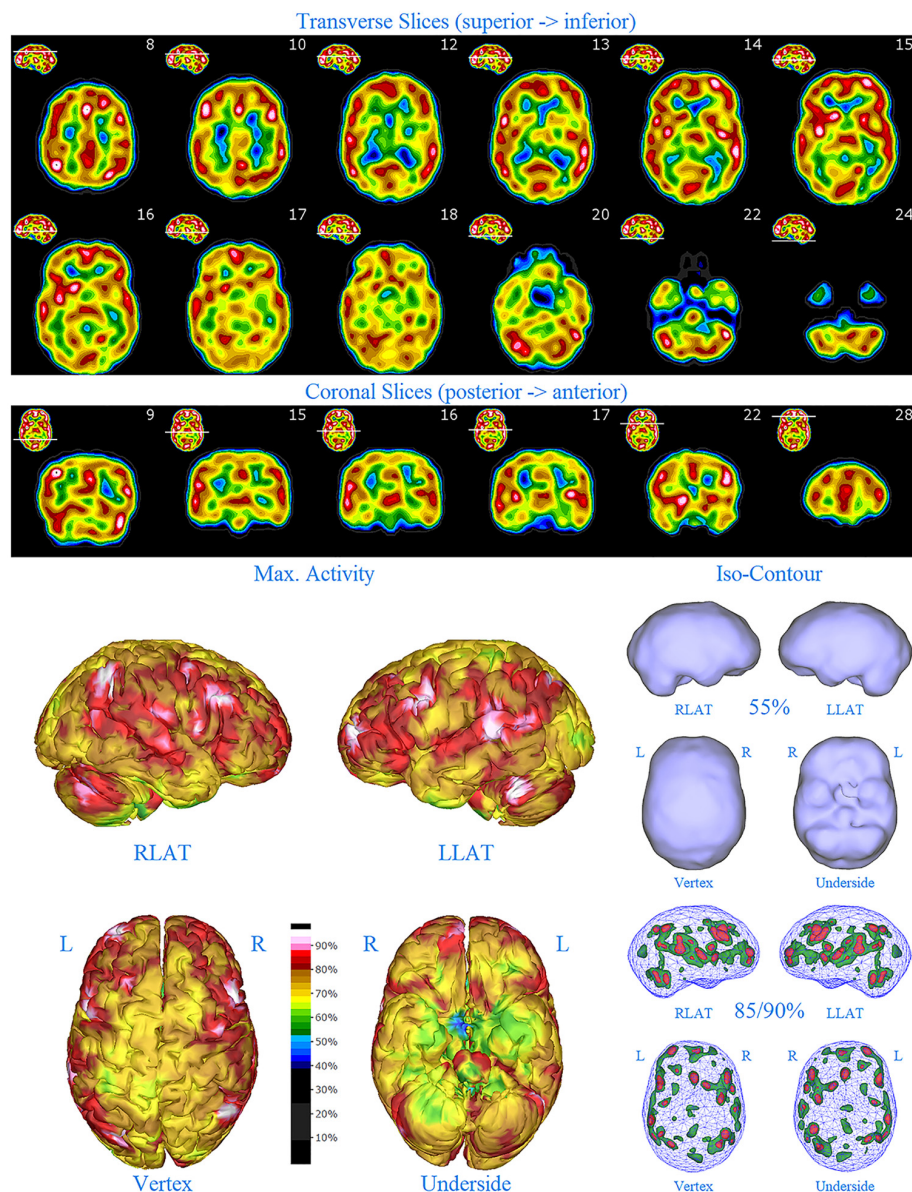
First perfusion SPECT scan of Patient C. Arrangement, color scales, and views are identical to Figure 1. Anatomical structures such as the thalamus are positioned similarly to the scan shown in Figure 2. Labeling was eliminated to avoid obscuring the scan details. Perfusion of the thalamus is essentially symmetrical. Perfusion is markedly increased in the right caudate. Multiple cortical areas of markedly increased perfusion are evident. For example, the highest signal is found in the right posterior parietal cortex (white area with black central dot in horizontal tomograms).
